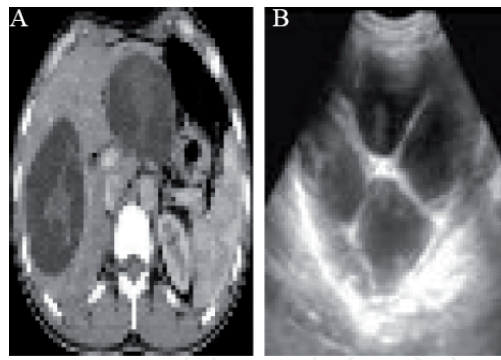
Type 2 hydatid cyst: (A) contrast enhanced computed tomography demonstrates multiple daughter cysts with irregular borders covering almost all of the volume of the mother cyst-so called “rosette appearance” and (B) oblique ultrasonogram in a 39 years old male demonstrates type 2 hydatid cyst.
